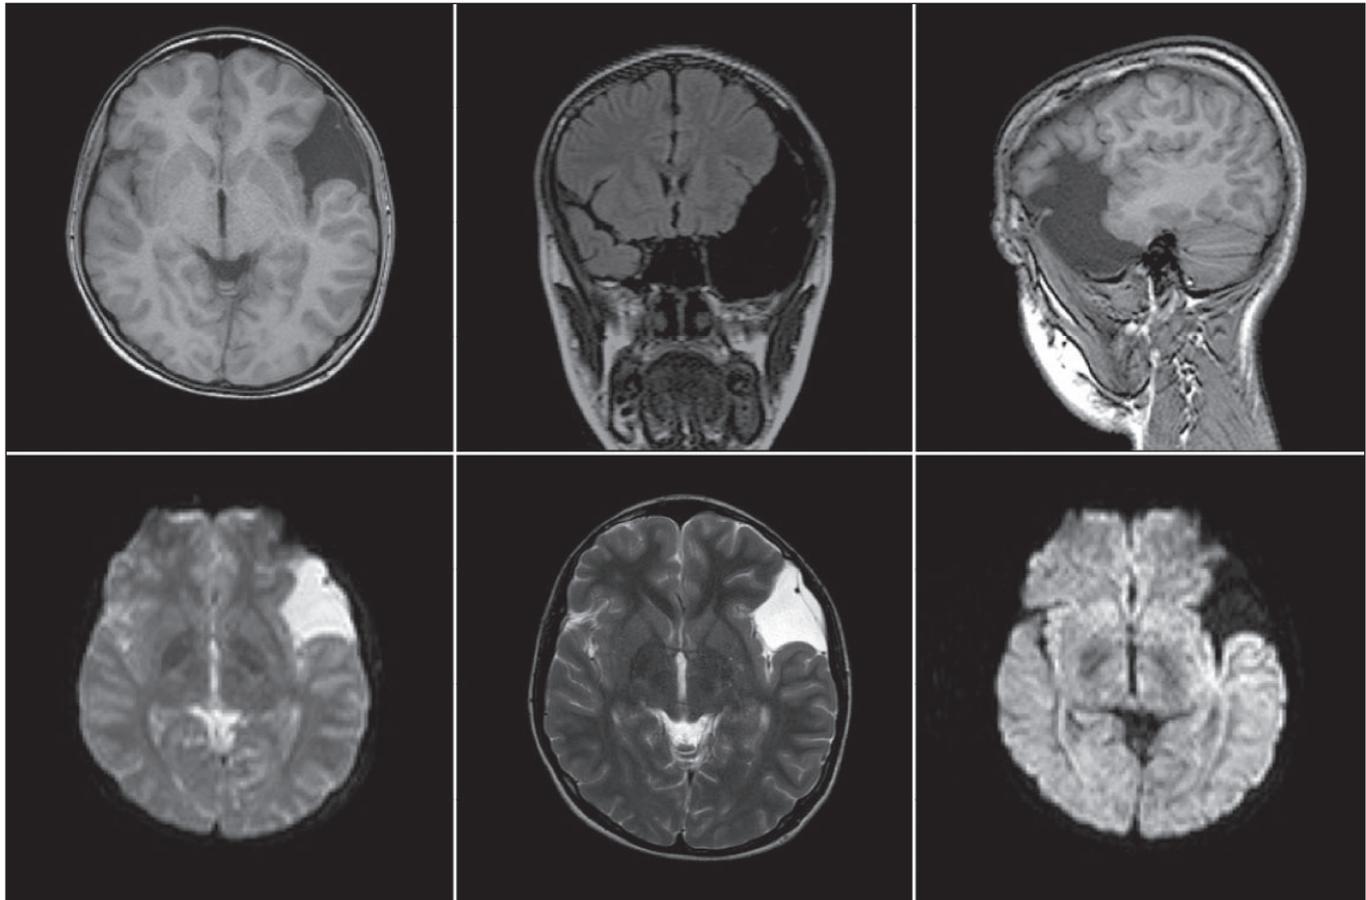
Postoperative MRI of the existing left temporal Sylvian arachnoid cyst with the resolution of the subacute subdural haematoma and the intracystic haematoma.
